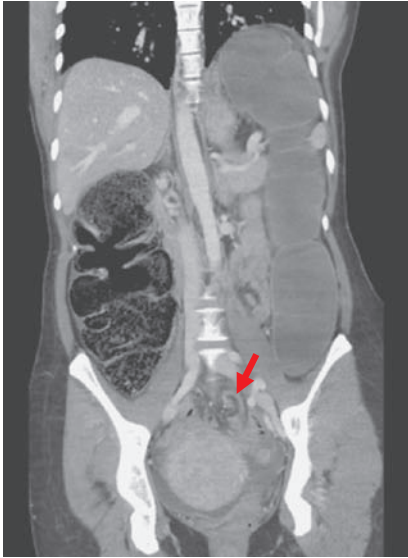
Coronal CT scan section. Sigmoid volvulus with the “swirl sign.”
